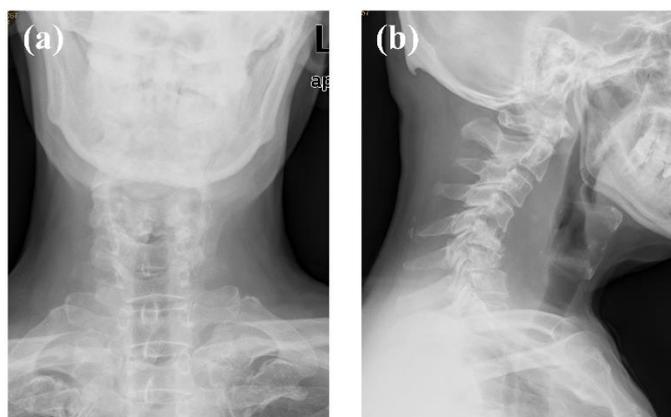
The preoperative X-ray shows that the cervical vertebra reverse arch, the C5 vertebral body moves backward, hyperosteoecy and cuspidation can be seen at uncinate joint and the posterior and anterior edge of C5-7 vertebral body, and the corresponding intervertebral space is narrowed.
